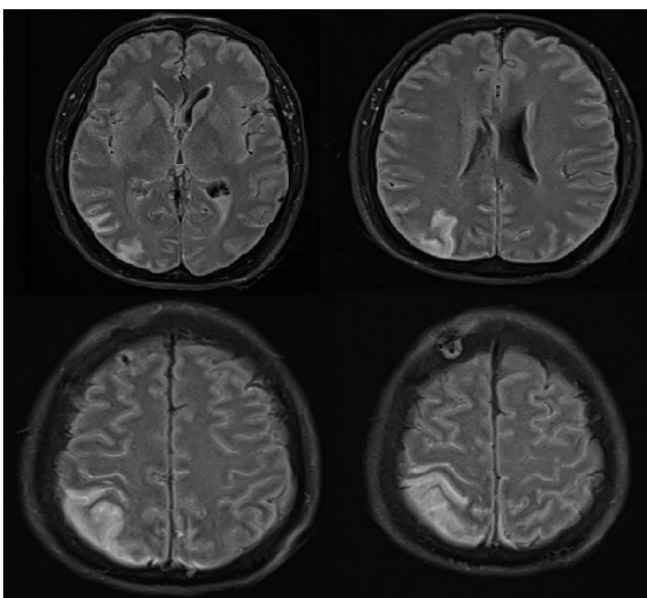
Brain magnetic resonance imaging demonstrating acute infarcts in the right parietal and occipital lobes
